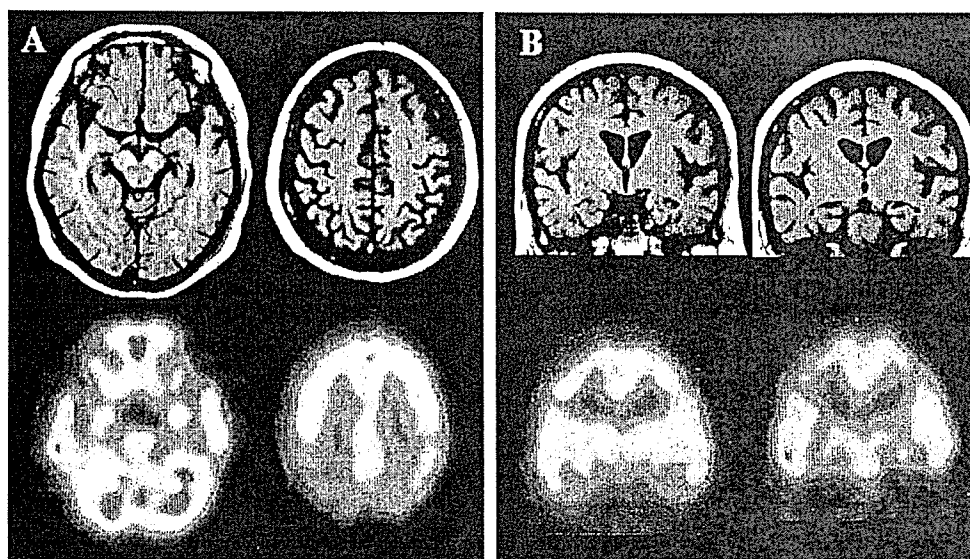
MRI (T1 weighted image) and SPECT (^{99m}Tc -ECD) findings. (A) Axial T1 weighted images show apparent occipito-parietal atrophy and mild atrophy in internal portion of temporal lobes. Axial SPECT images show marked hypoperfusion in bilateral occipito-parietal areas and internal portion of temporal areas. (B) Coronal images show slight atrophy in bilateral hippocampal areas, whereas coronal SPECT images show apparent hypoperfusion in the internal portion of temporal areas including bilateral hippocampal areas.
